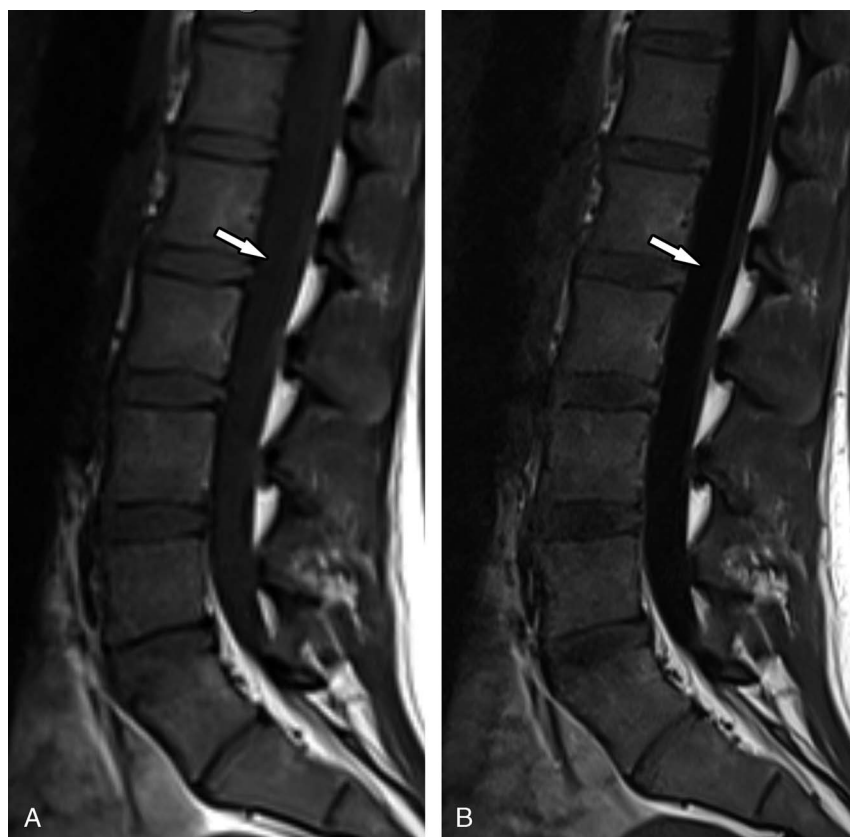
Nulling of the cerebrospinal fluid signal at 3.0 T. A, Sagittal conventional T1-weighted TSE 3.0-T MRI scan of the lumbar spine demonstrates suboptimal signal hypointensity (arrow) of the cerebrospinal fluid within the thecal sac. B, Sagittal T1-weighted TSE 3.0-T MRI scan with additional fluid-attenuated inversion recovery (FLAIR) facilitated improved signal hypointensity (arrow) of the cerebrospinal fluid within the thecal sac. Note the overall low signal intensity of the vertebral body bone marrow due to higher contents of red marrow. The MRI scans were obtained with a commercial 3.0-T MRI system (slew rate, 200 T/m/s; gradient strength, 60 mT/m) and spine coil array.
